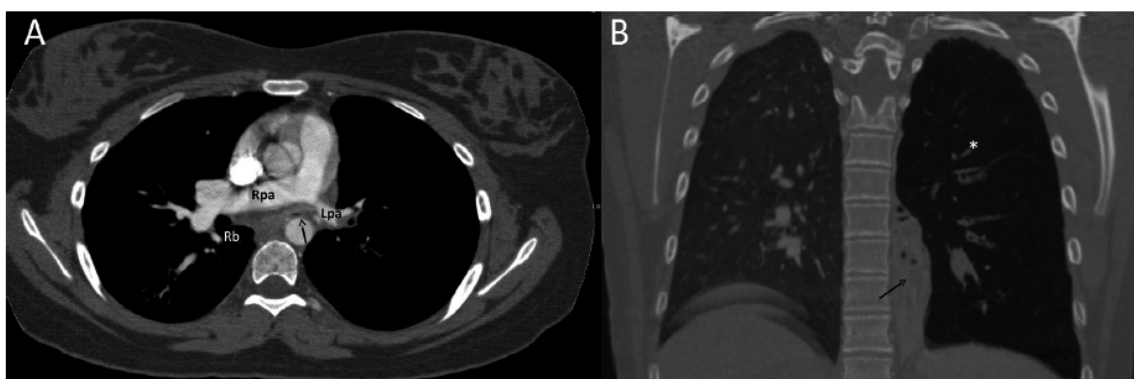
A, Axial multidetector computed tomography image with intravenous contrast (mediastinal window) showing the right bronchus (Rb), the narrowed left bronchus (arrow), hypoplastic left pulmonary artery (Lpa) and hyperplasia of the right pulmonary artery (Rpa). B, Coronal multiplanar reformatted MDCT image (lung window) showing area of consolidation (arrow) and hyperlucency (asterisk) in the left lung.
